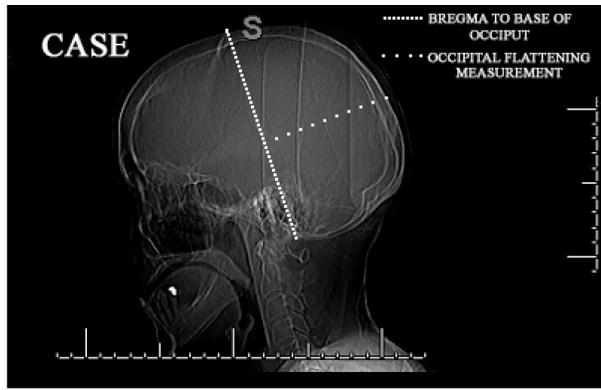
The sagittal scout images of CT scans of a patient with Moyamoya disease and age/gender/race matched control demonstrating measurement of bregma-occipital diameters.
